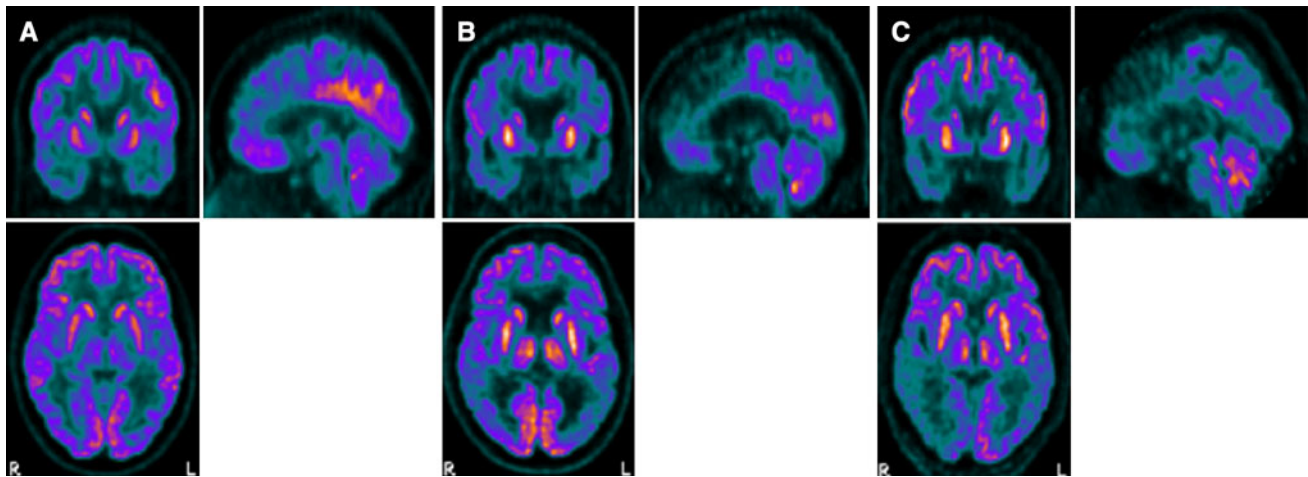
Images showing normal [^{18}F]FDG distribution in a healthy subject (a), and reduced uptake in posterior brain areas in an MCI subject (b) and a DLB subject (c). This reduced uptake is particularly evident in the occipital areas of the DLB patient (color figure online)
